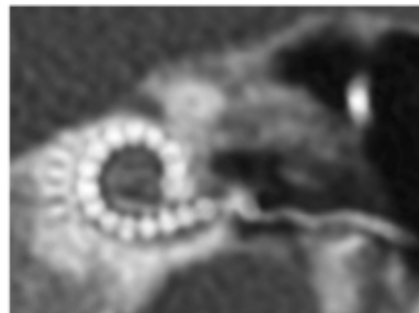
Postoperative spiral CT (CT) imaging reformatted in the oblique coronal plane demonstrating the intracochlear electrode array (Connor et al., 2018)
